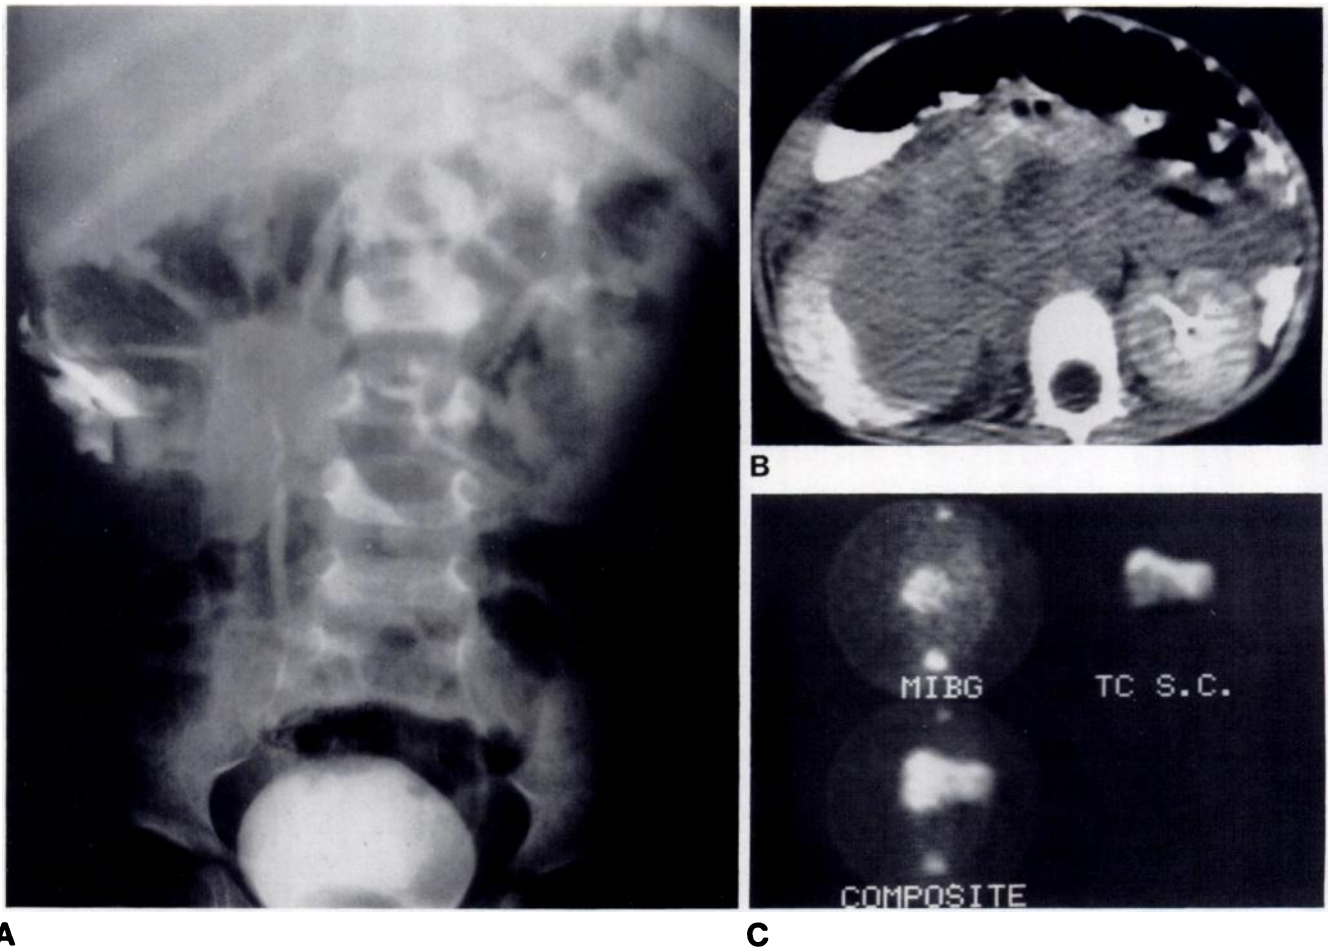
A, Excretory urogram. Inferolateral displacement of right renal collecting system indicative of suprarenal mass. B, Transverse CT scan after oral and intravenous contrast administration. Posterolateral displacement and invasion of right kidney by large soft-tissue mass that obscures normal retroperitoneal anatomy. Encasement of aorta and inferior vena cava is suggested. C, Computer acquired and displayed ^{99m}Tc sulfur colloid (S.C.) and MIBG
